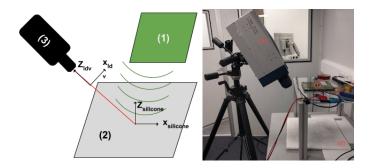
Experimental Set-up. (1) The ultrasound phased array, (2) the silicone slab and (3) the Laser Doppler Vibrometer
